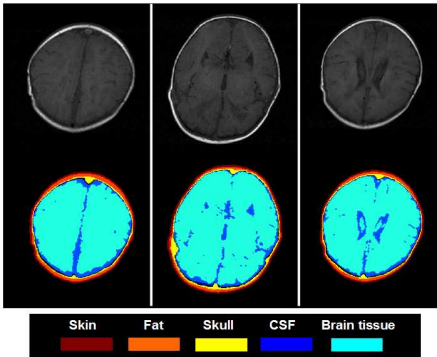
2D segmentation of the head of a 39 weeks old infant. Upper row shows original T1w MRI images and the lower row presents the segmented images. At the bottom is given explanation of the labels.
